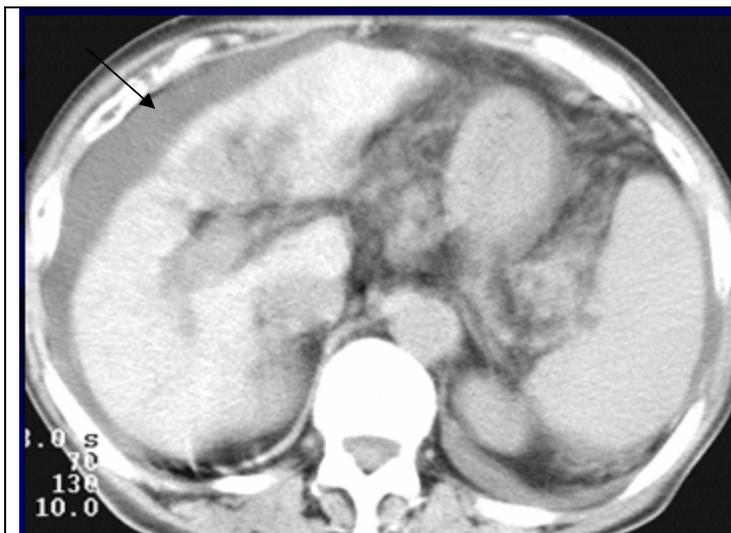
CT also shows heterogeneity of hepatic frame, roughness of contours, presence of ascites (arrow).
